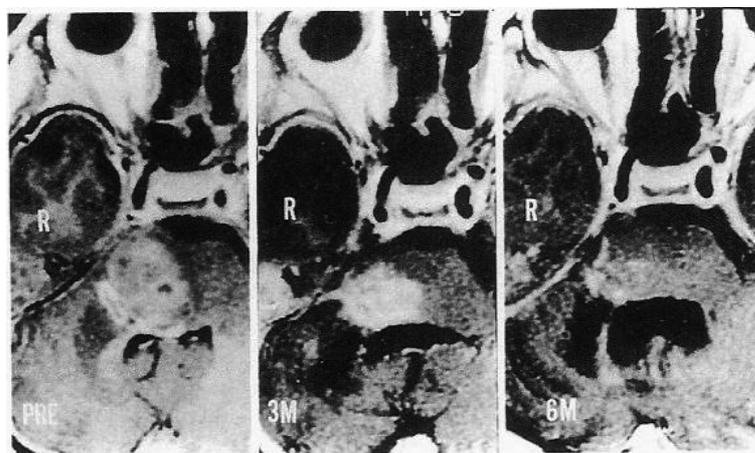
Results of a case of a pontine glioma (protoplasmic astrocytoma) before (a) and after (b,c) pritumumab therapy (33). (a), Gd-enhanced MR image shows an irregularly enhanced tumor with peritumoral edema to the right of the pons and a markedly deviated IVth ventricle. The same tumor after 3 months (b) and after 6 months (c) of pritumumab therapy. The Gd-enhanced MR images show that the tumor has decreased in size and that the deviation of the IVth ventricle has been corrected.
